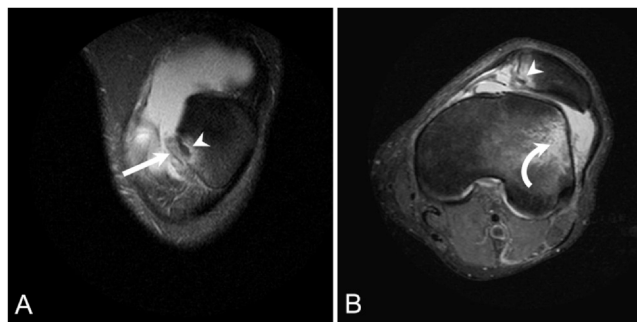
Competitive soccer player presents for an MRI following a knee contact injury. Coronal T2 FS (A) and axial T2 FS (B) MR images through the patellofemoral compartment show an osteochondral impaction fracture at the inferomedial patella (arrowhead in A and B) with an adjacent small, mildly displaced osteochondral fragment (arrow in A). There is an associated acute osseous contusion (ie, “bone bruise”) along the anterior lateral femoral condyle (curved arrow in B), confirming the diagnosis of a transient lateral patellar dislocation. FS, fat saturation; MR, magnetic resonance; MRI, magnetic resonance imaging.
